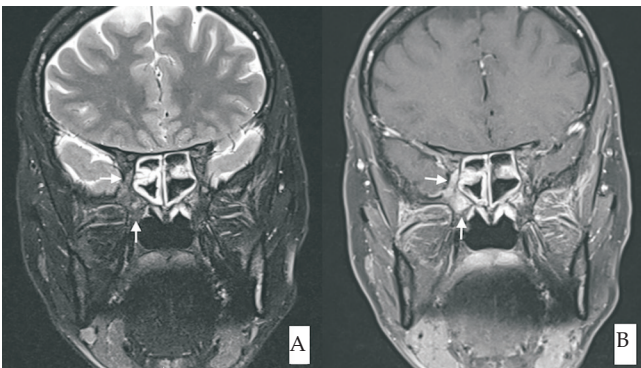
Coronal plane orbital T2 weighted fat-suppressed magnetic resonance image (A) of a 6-year-old female patient at the time of diagnosis showed expansile iso-hypointense lesion (arrows) involving the left lacrimal gland, left superior and lateral rectus muscles. Post-contrast T1 weighted fat-suppressed magnetic resonance image (B) revealed diffuse contrast enhancement in this lesion (arrow). After the systemic corticosteroid therapy for two weeks, coronal plane T2 weighted fat-suppressed magnetic resonance image (C) and post-contrast T1 weighted fat-suppressed magnetic resonance image (D) revealed remarkable regression in this lesion (arrow).
